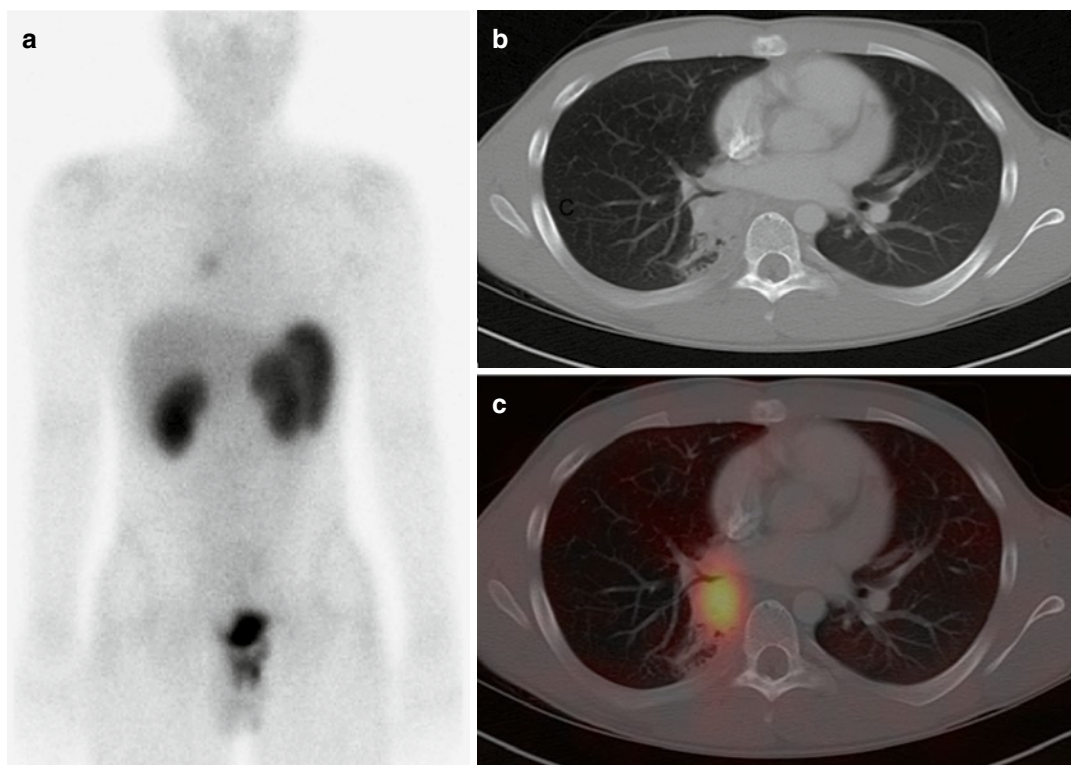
Indium-131-pentetreotide scan of an endobronchial carcinoid. (a) Whole-body ^{111}In -pentetreotide scan in the anterior projection shows a focus of abnormal moderate uptake near the right hilum. (b) Chest CT shows a 2 cm mass
